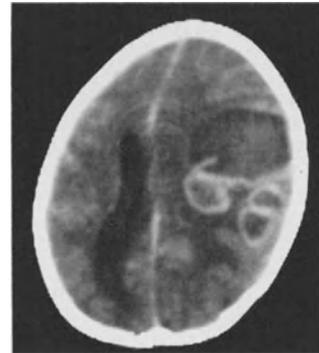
CT of multiple right temporo-parietal brain abscesses in a 7-year-old girl with tetralogy of FALLOT. Treatment by large osteoplastic trepanation and removal of 50 ml pus
